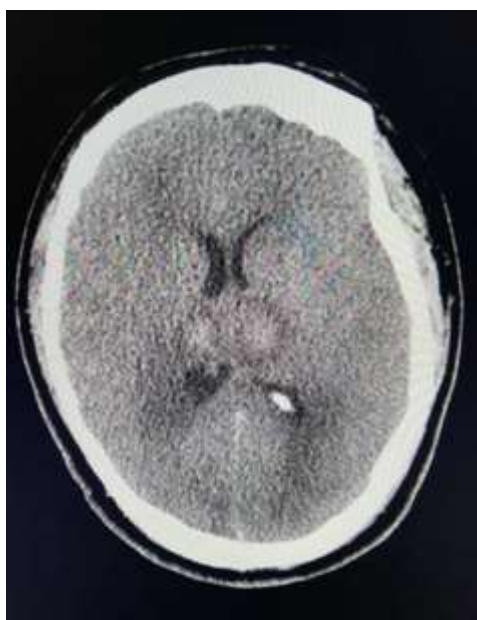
STAT CT brain from 05:30 on the second hospital day showing bilateral thalamic infarctions and diffuse cerebral edema with effacement of the sulci and loss of grey/white differentiation.
